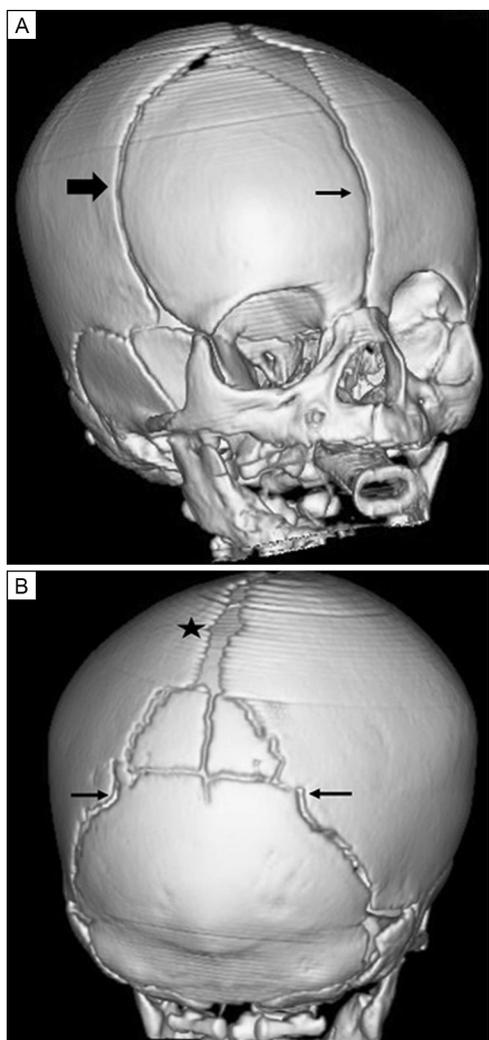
A 3D reconstruction computed tomography (CT) scan showing. A, Normal patent metopic (line arrow) and right coronal suture (block arrow) in a 1-month-old baby. B, Normal patent sagittal (star) and bilateral lambdoid (line arrows) sutures.
